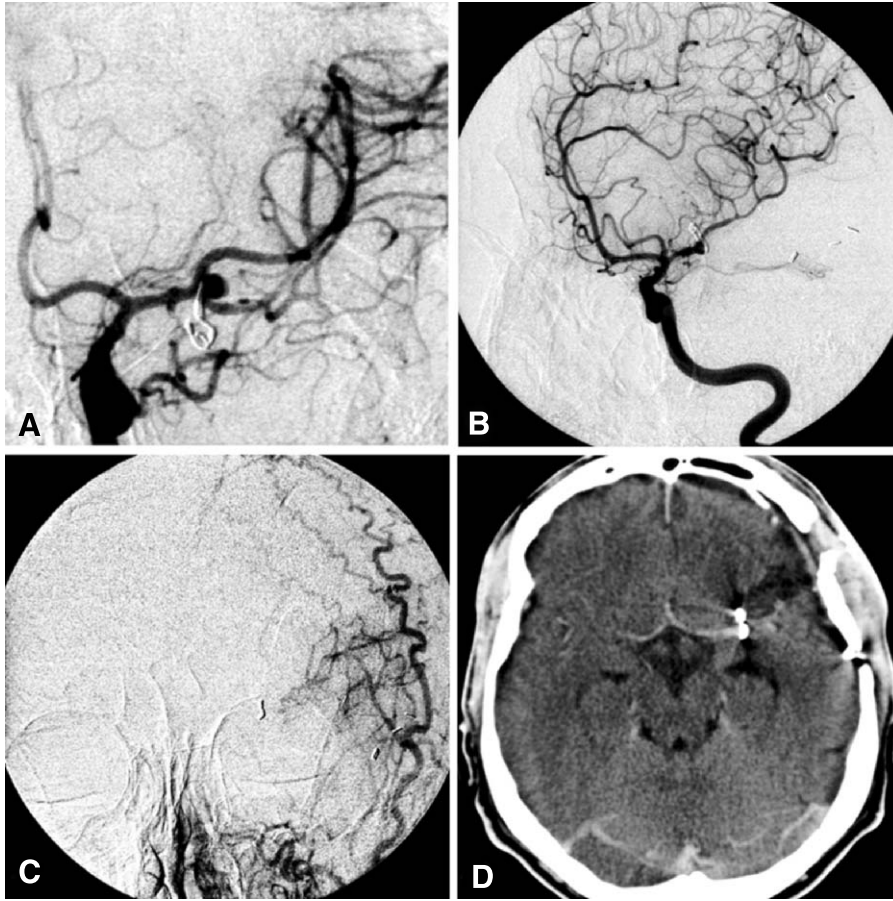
Case 2 Angiography showing the previously operated MCA aneurysm with filling of the pseudoaneurysm (A). Angiography showing the functioning bypass (C) and occlusion of the inferior MCA trunk (B). CT scan after surgery (D) with slight hypodensity in the area of the sylvian fissure but no other signs of ischemia
